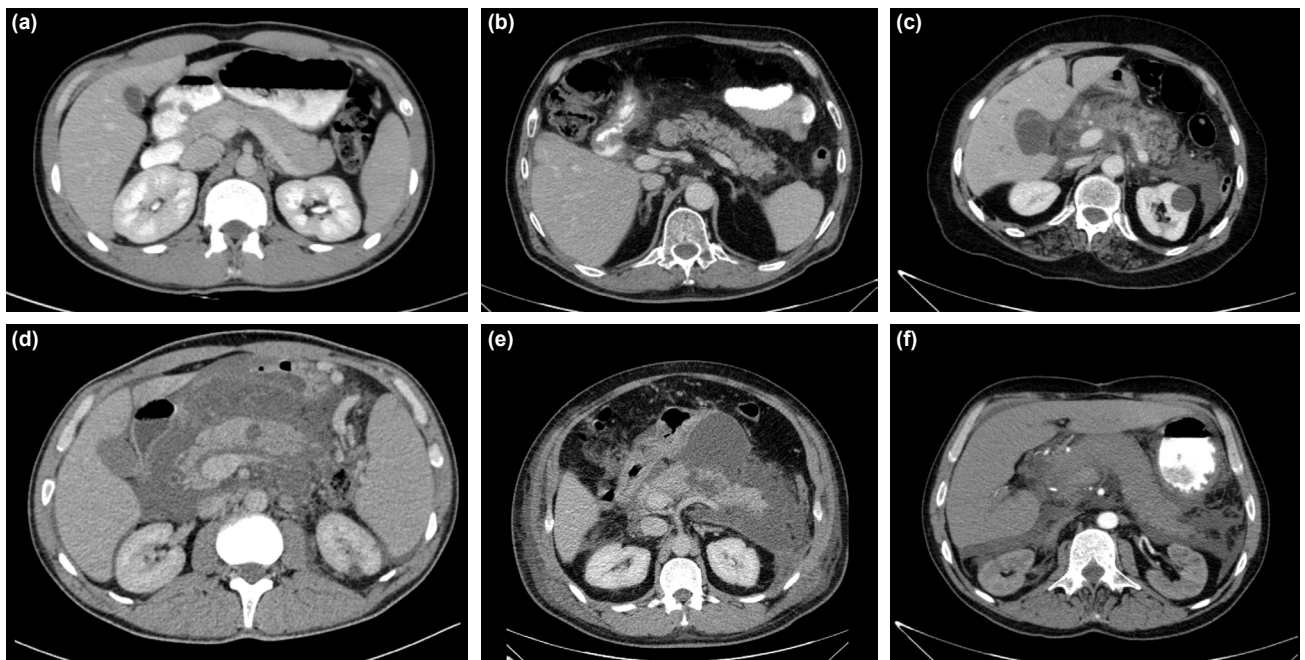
(a) A coronal section of the abdominal CT scan shows normal pancreatic parenchyma with homogeneous contrast enhancement. (b) Inflammation of the peripancreatic fatty tissue, parenchymal contrast enhancement still homogeneous. (c) Edematous and homogeneously enhanced effusions around the pancreatic parenchyma extending to the right and left pararenal areas. Effusion is chosen in the pericholecystic area. There is an incidental cyst in the left kidney. (d) The non-enhancing necrosis area is selected in the middle of the pancreatic body with significant retroperitoneal and intraperitoneal (perihepatic and perisplenic) effusions. (e) Areas of non-enhancing necrosis on the pancreatic body and tail (not shown) are noted. There are fluid collections in the bilateral pararenal area and the lesser sac. (f) Edematous and non-enhancing pancreatic parenchyma with bilateral pararenal effusions.
